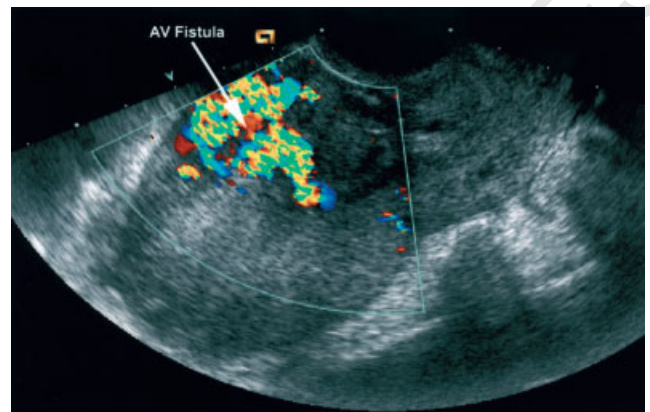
Color Doppler image of the arteriovenous malformation.
